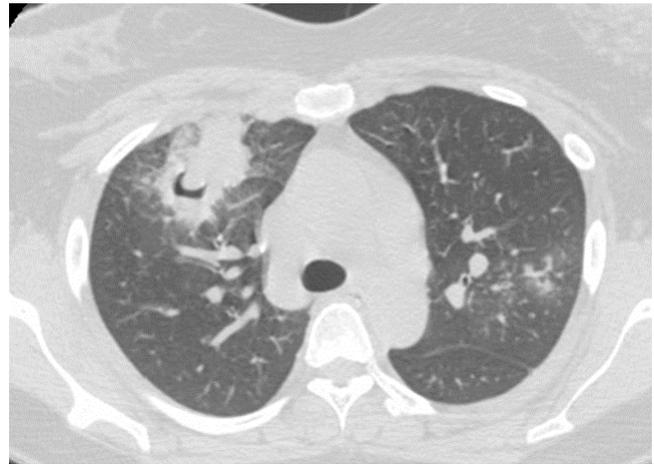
A 27-year-old female with underlying acute myeloblastic leukemia and neutrophils 3,171 cells/mm³ presented with fever. Axial thoracic CT scan demonstrated a crescent shaped area within an area of consolidation that represented air crescent sign at right upper lobe. Ground-glass nodules at left upper lobe were also noted. The final diagnosis was invasive pulmonary aspergillosis.
